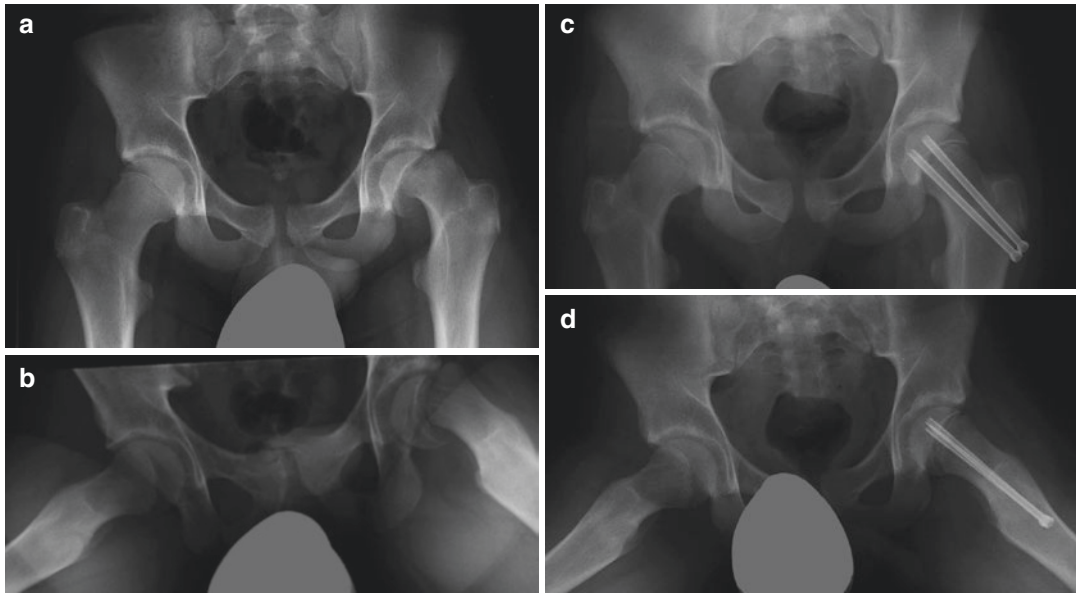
(a) Anteroposterior pelvic X-ray, and (b) frog-leg lateral X-ray of an acute slip of the left hip. (c) Anteroposterior pelvic X-ray, and (d) frog-leg lateral
